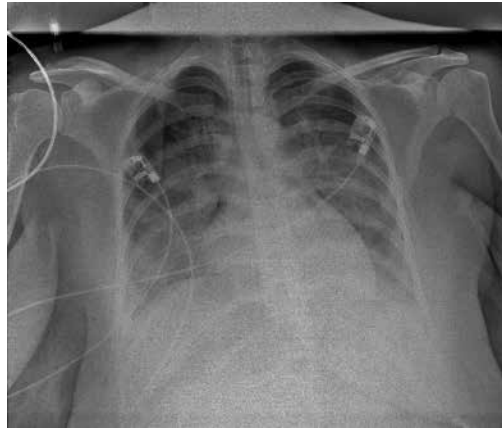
The patient's anterior-posterior chest x-ray on the second day
